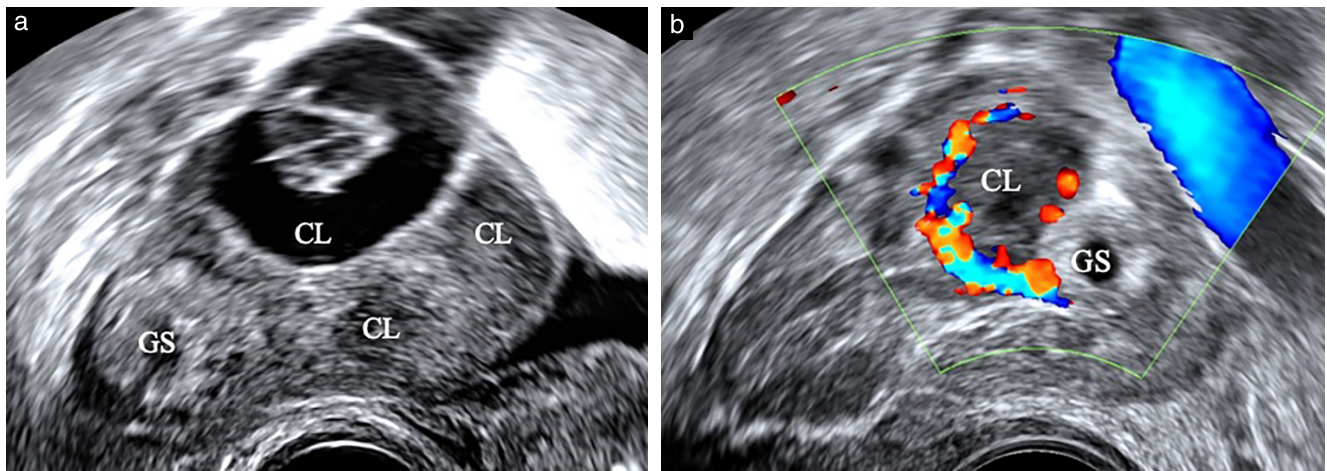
Grayscale (a) and color Doppler (b) transvaginal ultrasound images of ovarian ectopic pregnancies, demonstrating: (a) gestational sac (GS) seen separately to multiple corpora lutea (CL); and (b) vascularity of CL seen separately to GS.
